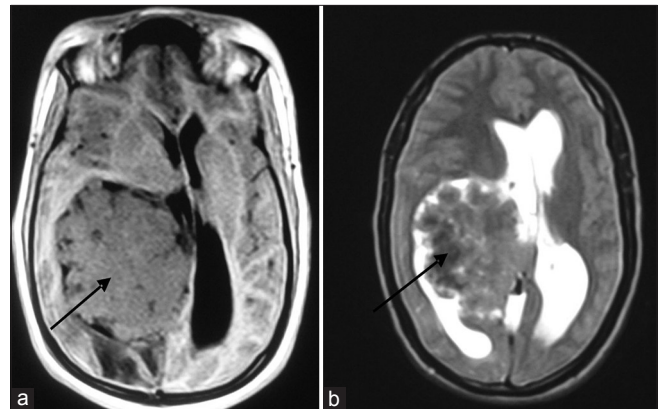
(a) (Pre contrast) T1-Weighted and (b) T2-Weighted Axial MR images. A lobulated right lateral ventricular mass is seen which iso-hypointense on T1 and T2 Weighted images. It is surrounded by a cleft of CSF and shows peritumoral edema and midline shift to the left side. The ipsilateral anterior horn, third ventricle, internal capsule and caudate nucleus are compressed
